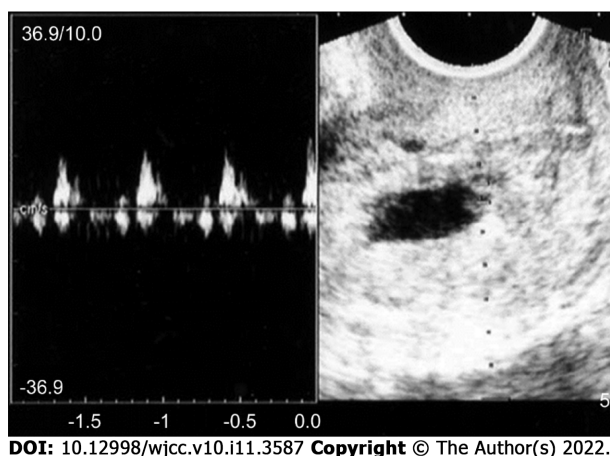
Transvaginal ultrasound findings in Case 1. A gestational sac with fetal heartbeat was found in the cervix.
